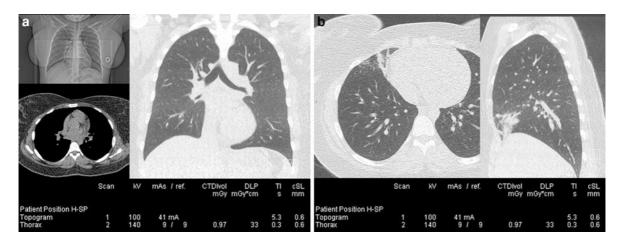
Low-Dose chest CT examination acquisition obtained in a 23-year-old teacher with suspected tuberculosis. Tube potential is at 140 kV, mean effective tube current time product is 9 mAs, and the CTDIvol is 0.97 mGy. DLP is at 33 mGy.cm. Three millimeter slices are reconstructed with iterative
